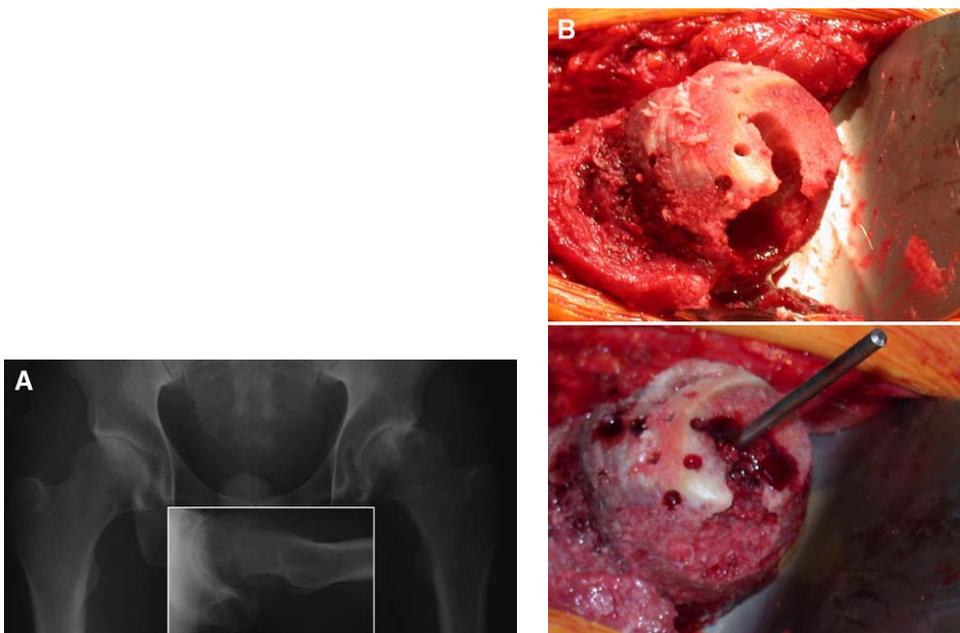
(A) Forty-five-year-old man with an arthritic hip associated with a large femoral head cyst seen on anteroposterior radiograph and cross-table lateral radiograph (*inset*). (B) Intraoperative photographs after femoral head preparation showing the size of the cyst pre- (*upper panel*) and postgrafting (*lower panel*) with acetabular and femoral head reamings.
